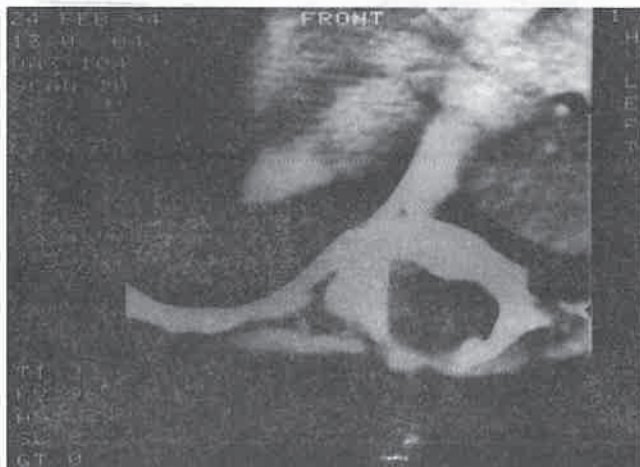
CT-scan showing postoperative spinal cord at thoracic 10.
